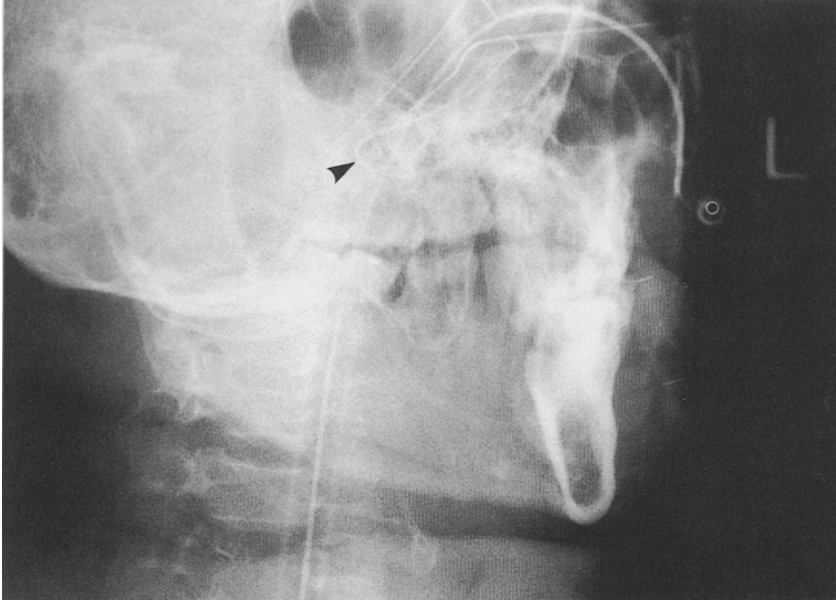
The loop (*arrow*) of the nasogastric tube around the endotracheal tube is seen in the upper pharynx. This X-ray was taken soon after the end of the operation. At that time, there was no knot in the nasogastric tube. The knot in the nasogastric tube may have formed after several failed attempts to remove the tube from the nose
